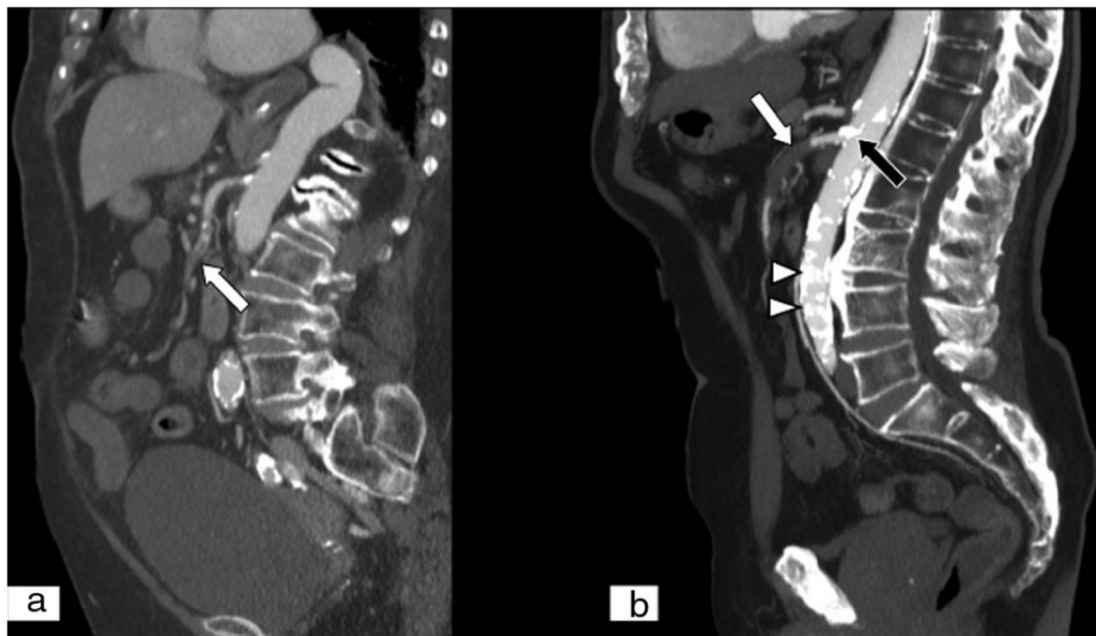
(A) SMA embolism in multiplanar reconstruction CT: distal localization of the embolus, (B) SMA thrombosis in multiplanar reconstruction CT: ostial localization of the thrombus
